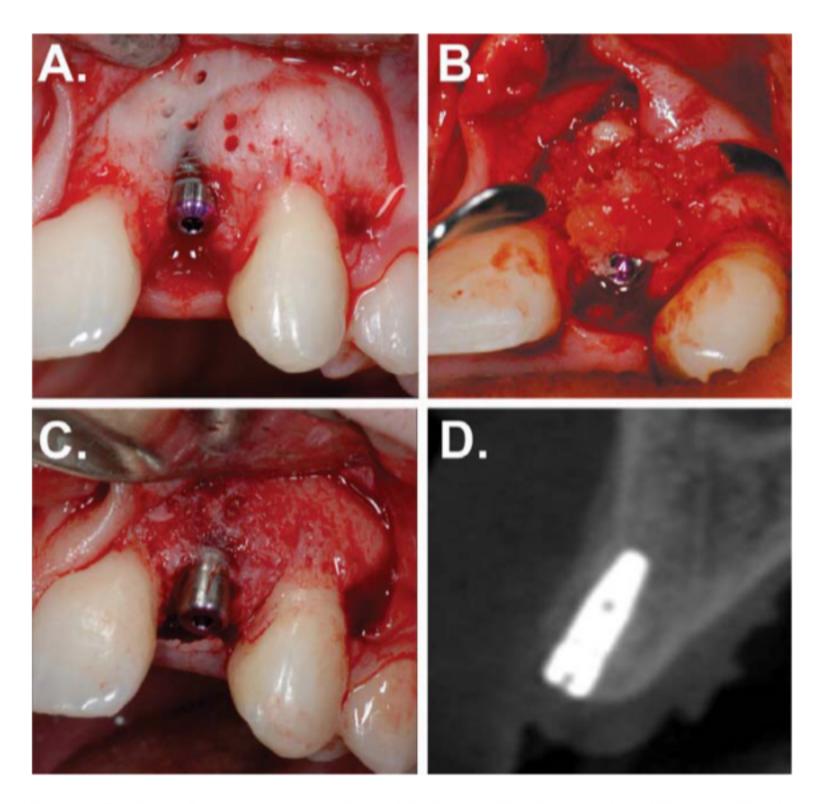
Horizontal bone augmentation with Osteocel[®]. (A) Clinical view showing the dental implant dehiscence at the time of placement. Note intra-marrow penetrations have been made. (B) Clinical view with the cellular allograft in place. No membrane was utilized and the flap was sutured to tension-free primary closure with Vicryl[™] sutures. (C) The four-month post-operative clinical view showing 2–3 mm of lateral bone augmentation and complete coverage of the implant threads. (D) A four-month post-operative CT scan showing the regeneration of a 2–3 mm thick buccal plate of bone over the implant.
